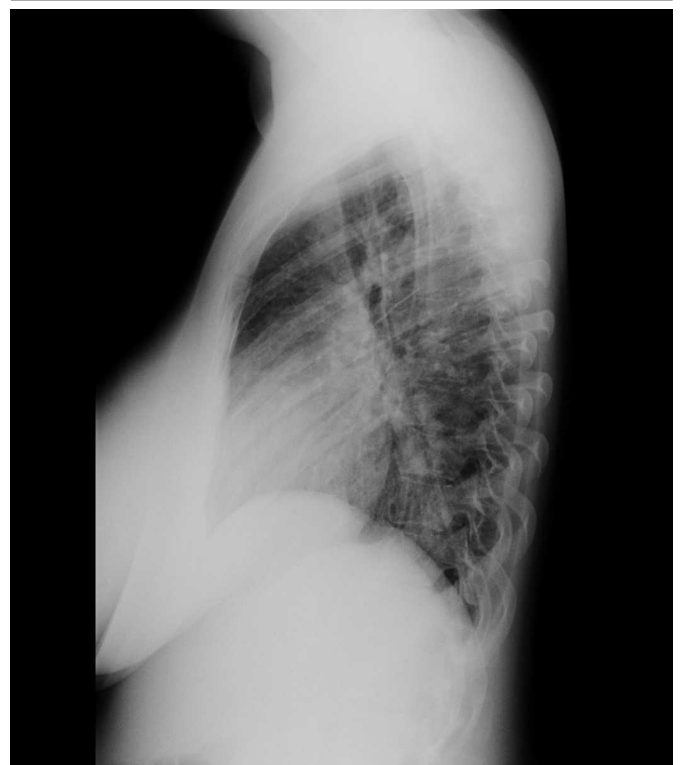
Lateral view of the chest radiograph
